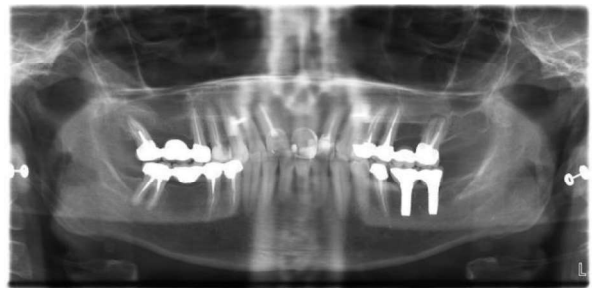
x-ray follow-up after 10 months
